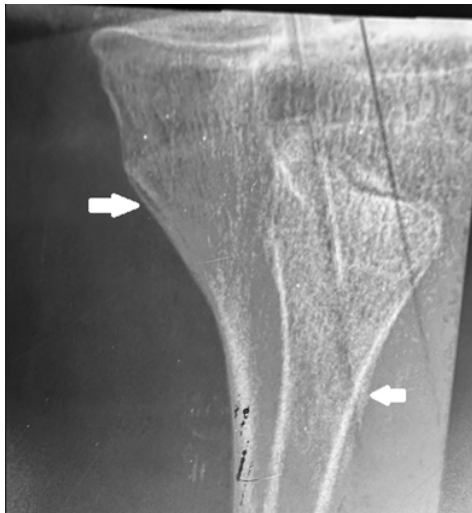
Xray of the leg (zoom) showing lamellar periosteal thickening of the tibia and fibula.
